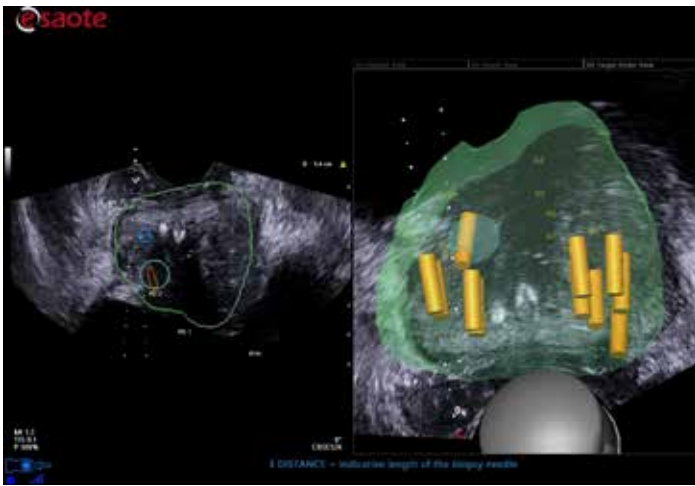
TR biopsy with the needle guide and sample mapping activated. In the MRI volume, the doctor can observe in 3D how the samples are distributed across the gland.
